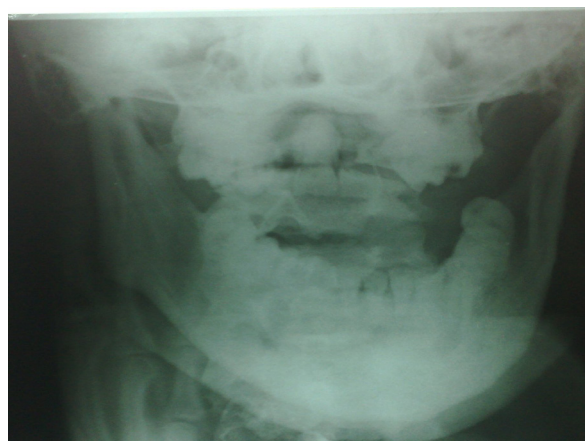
Anteroposterior x-ray view
